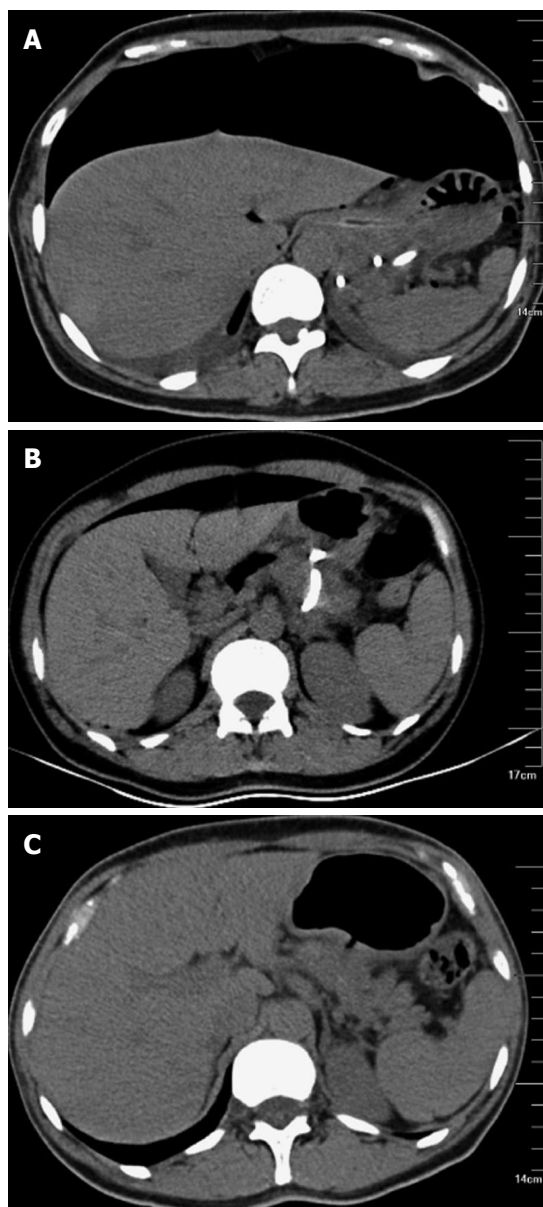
Computed tomography scan. A: Showing stent migration and pneumoperitoneum after 3 d of the procedure; B: After 3 d of the stent removal and replacement; C: Twelve weeks later.
